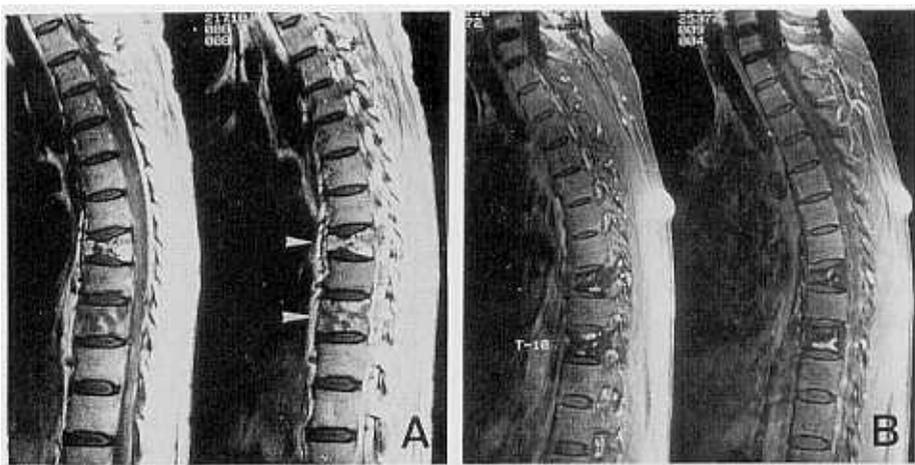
Initial T-spine MRI showing heterogeneously enhanced lesion by gadolinium injection at the T8 and T10 vertebra (A). After radiotherapy and the 3rd cycle of chemotherapy, follow-up MRI revealed possible fatty changes within the marrow space of T8 and T10 vertebral bodies, but there was still nodular and spotty enhancement after gadolinium injection (B).
